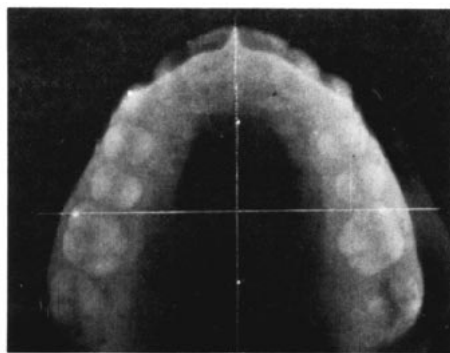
Occlusal x-ray of the plaster model.
